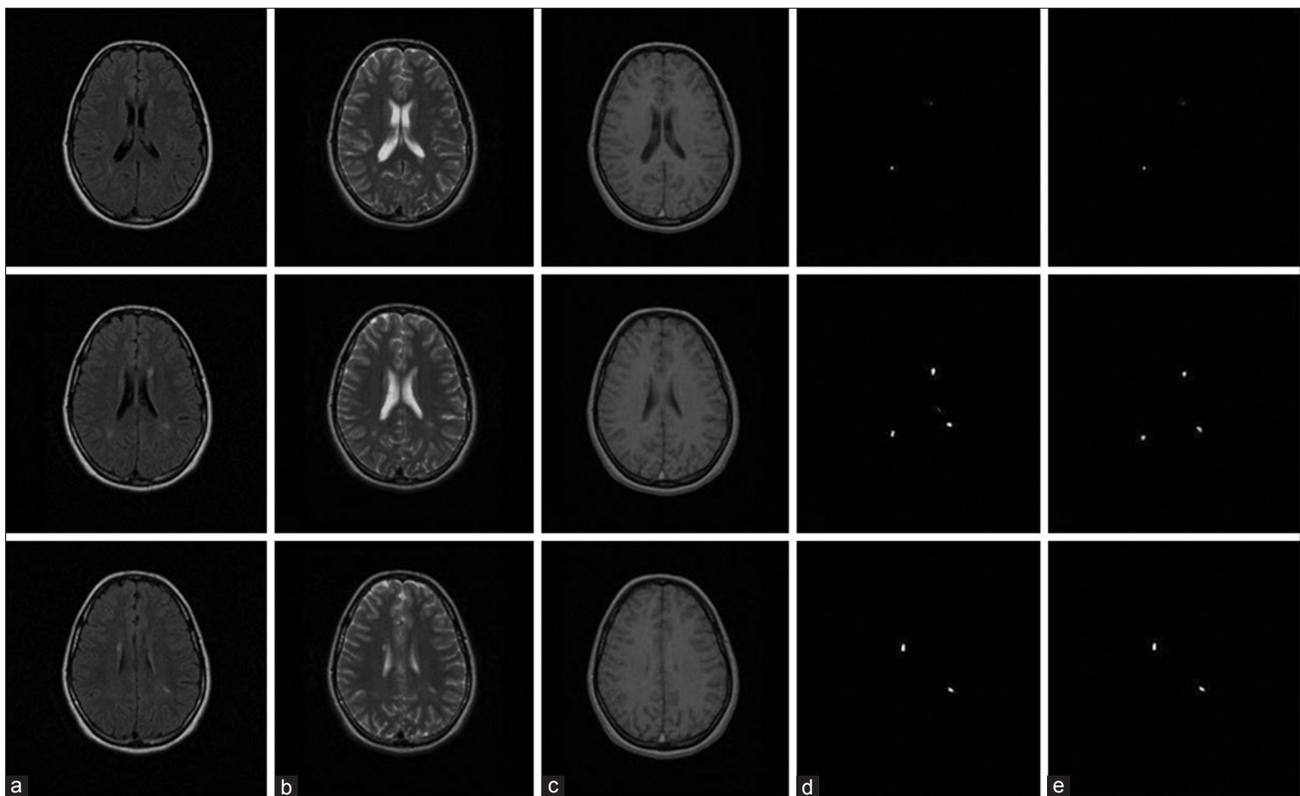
Segmentation of multiple sclerosis lesions in three slices of a real magnetic resonance images. (a) Original fluid attenuated inversion recovery image; (b) original T2 image; (c) original T1 image, (d) automatic segmentation of MS lesions by genetic algorithm–support vector machine method; (e) manual segmentation of MS lesions
